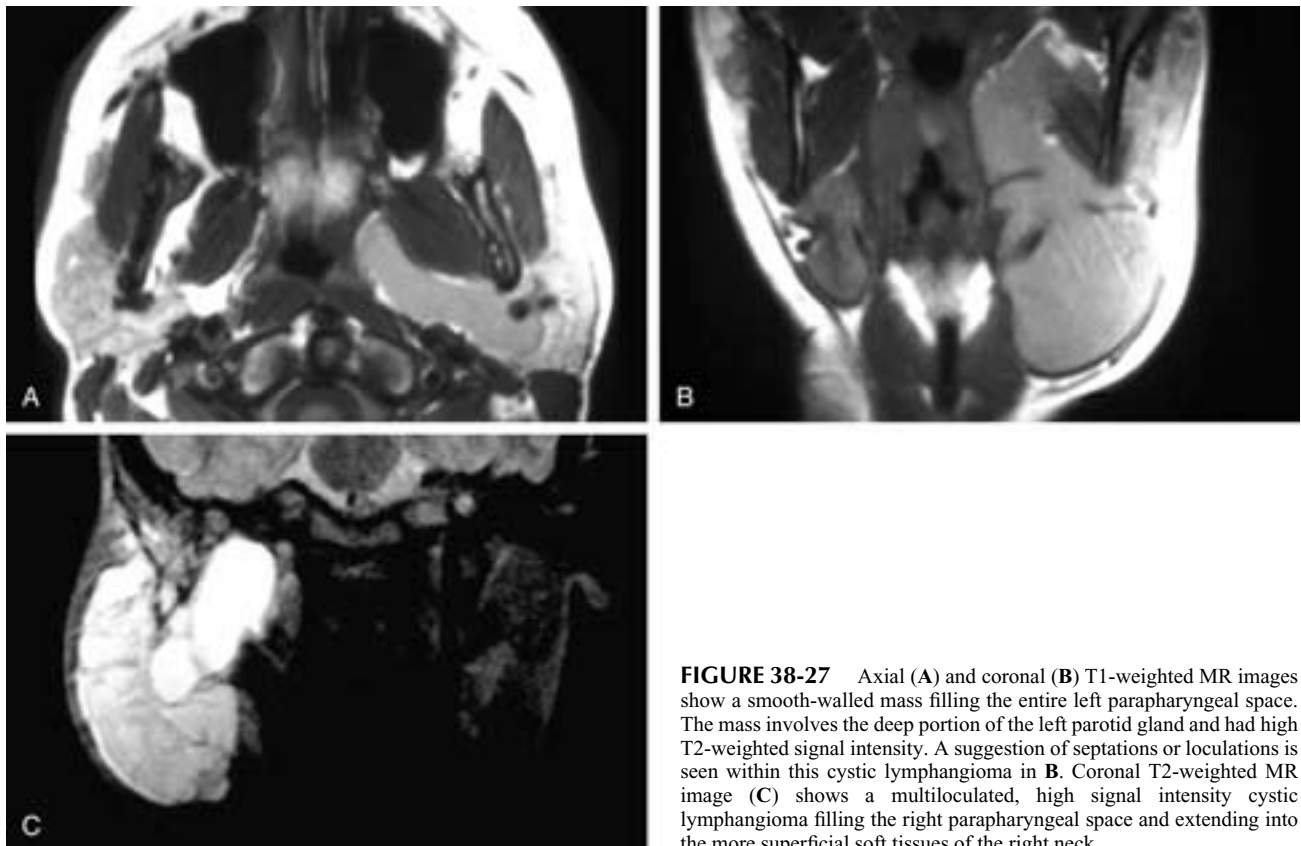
Axial (A) and coronal (B) T1-weighted MR images show a smooth-walled mass filling the entire left parapharyngeal space. The mass involves the deep portion of the left parotid gland and had high T2-weighted signal intensity. A suggestion of septations or loculations is seen within this cystic lymphangioma in B. Coronal T2-weighted MR image (C) shows a multiloculated, high signal intensity cystic lymphangioma filling the right parapharyngeal space and extending into the more superficial soft tissues of the right neck.
